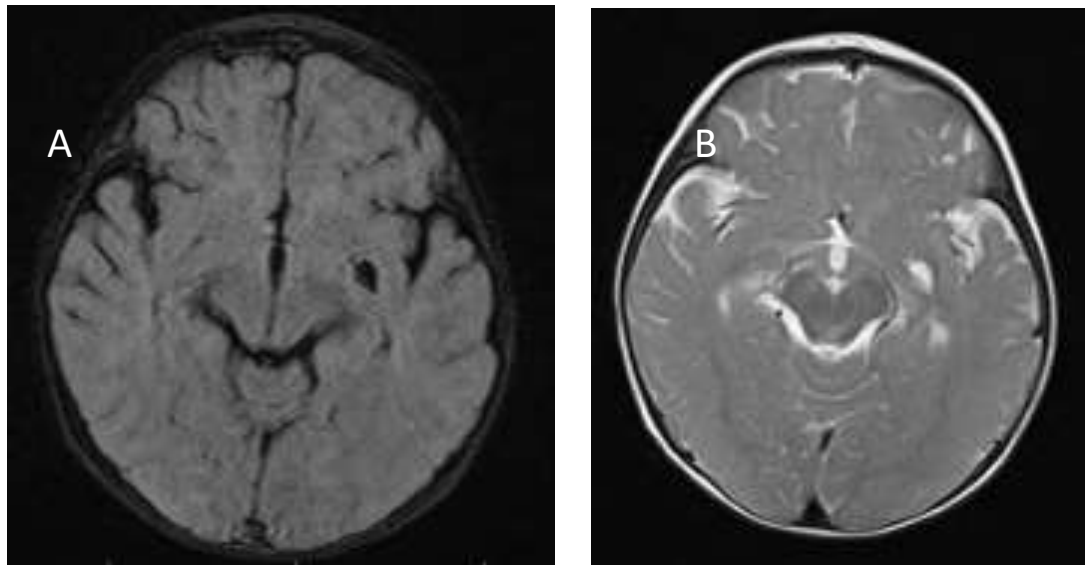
Brain MRI images. In an axial image of the brain, a small cyst in the left internal capsule is seen. (A) Fluid-attenuated inversion recovery image. (B) T2-weighted image
